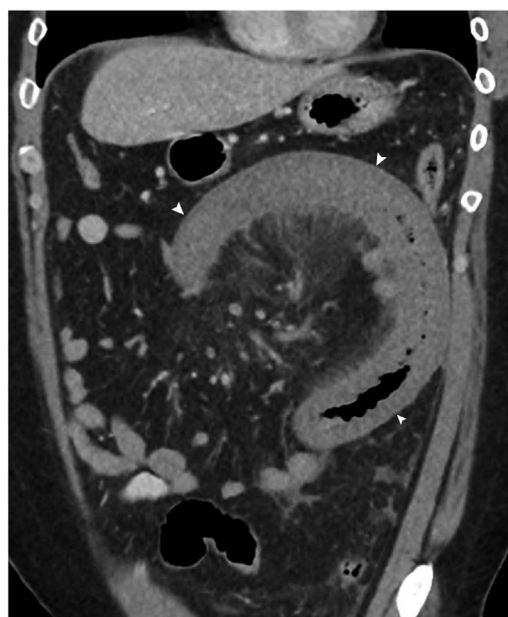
Coronal contrast enhanced computed tomography scan of the abdomen demonstrating dilated loop of jejunum with markedly thickened edematous wall (white arrowheads). Note associated mesenteric edema
